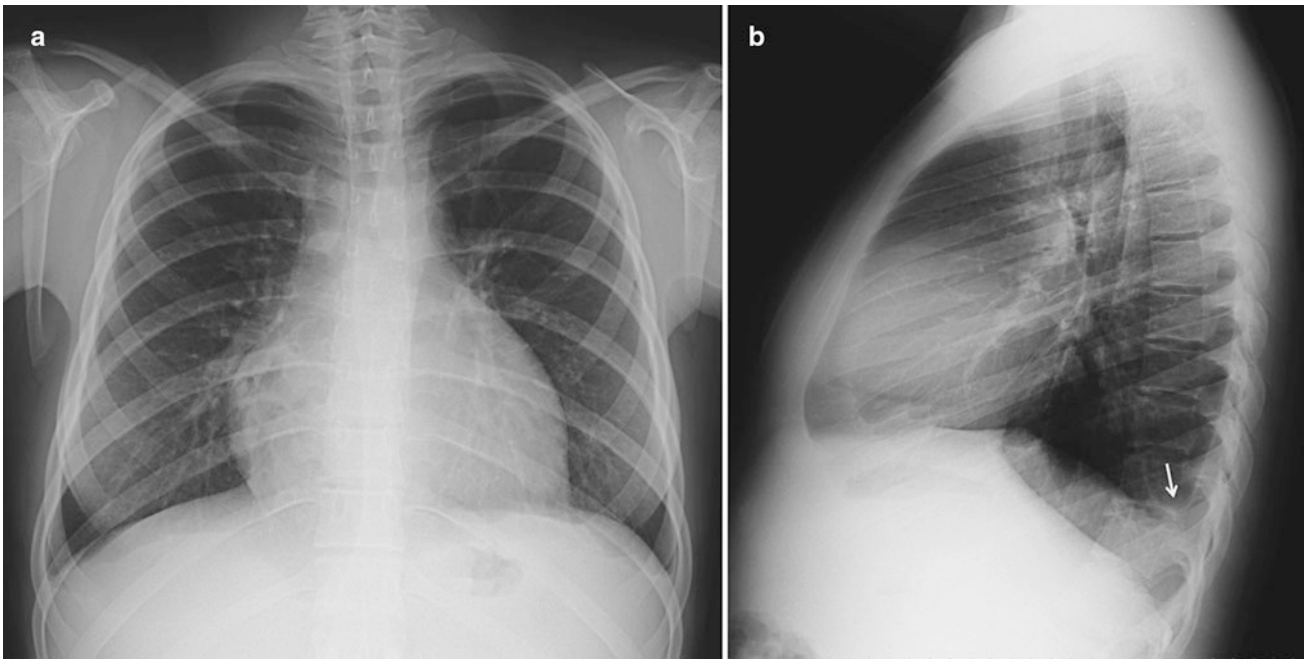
Frontal (a) and lateral (b) chest radiographs in a child with a small left pleural effusion shown on the lateral view by demonstrating blurring of the posterior costophrenic sulcus (arrow)
